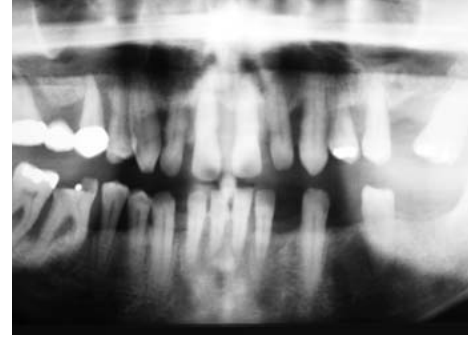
Figure 3: Periapical films preoperatively.
